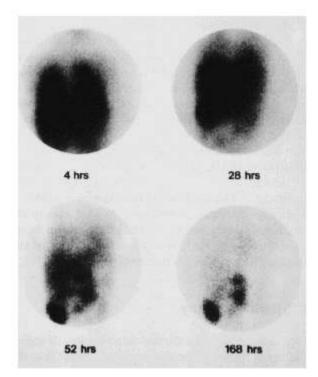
[131] MIBG therapy in a 4-year-old girl with neuroblastoma: repeated scintigraphy at different intervals demonstrates the concentration and retention of [131] MIBG by the tumor and the rapid clearance from the normal tissues.
